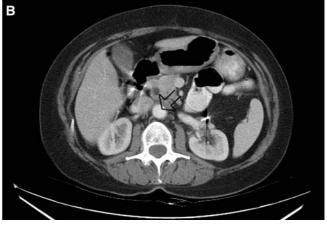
Computerized tomography (CT) scan images from a patient with Stage IV colorectal cancer demonstrating a partial response (PR) after six cycles of L-NDDP therapy. a Baseline abdominal CT scan showing a left-sided para-aortic metastatic mass. b Significant reduction in tumor volume after six cycles of L-NDDP monotherapy (arrow), demonstrating a PR according to the RECIST criteria
